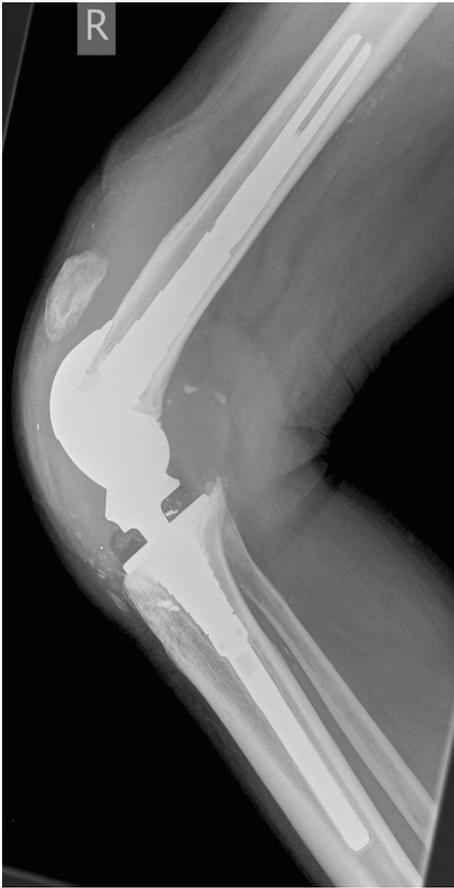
Lateral knee radiograph demonstrating extensor mechanism failure with patellar tendon rupture and passive traction of quadriceps causing a high riding patella
